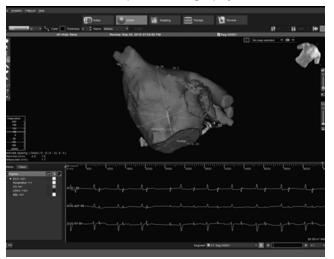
Image integration. Computed tomography was integrated with the Carto 3 system. Three diameters of the left atrium were measured: latero-lateral, antero-posterior and supero-inferior. With white color the coronary sinus can be visualized. The atrial appendage is an anterior structure that comes close to the anterior mitral ring.
